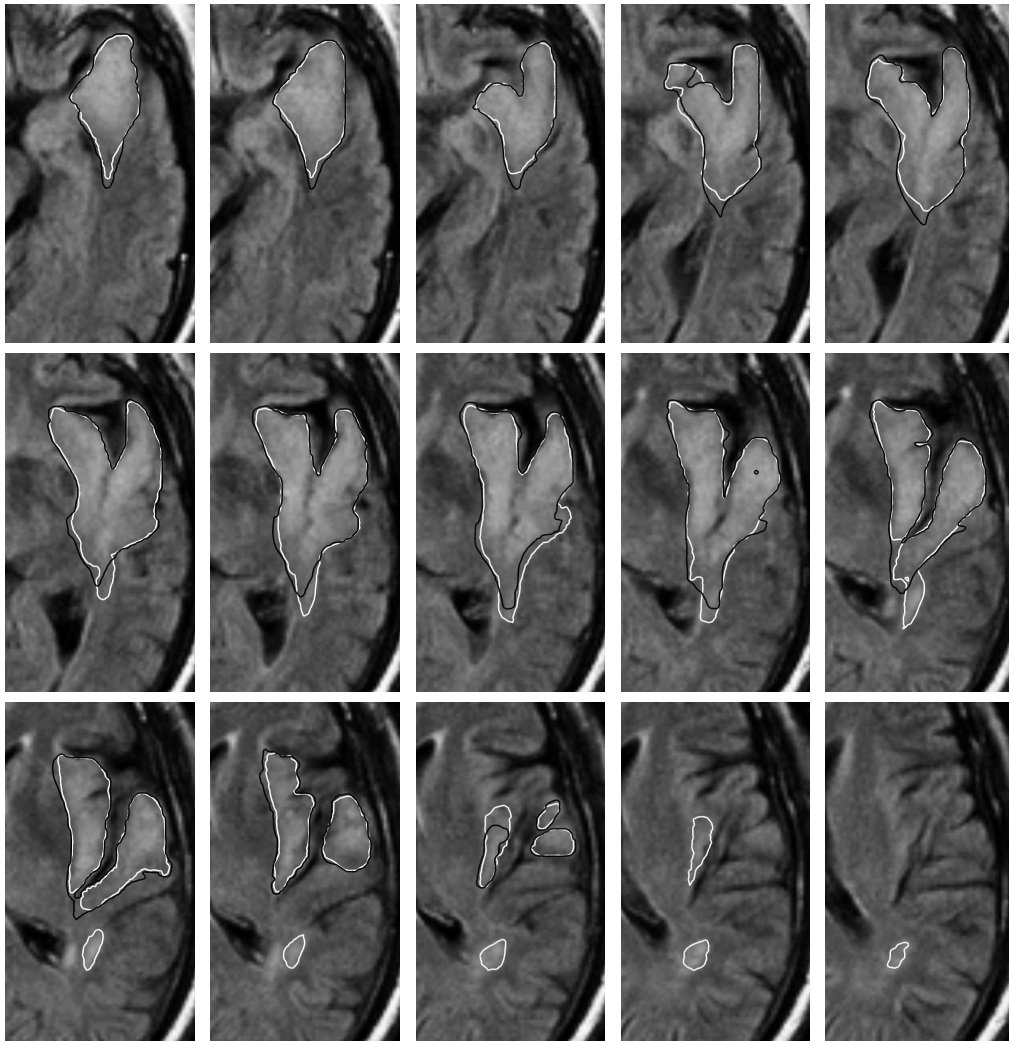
The MR image taken at the fourth time point for the second patient. The white contour denotes the manual delineations and the black contour is the estimated evolution of the tumor delineation.
